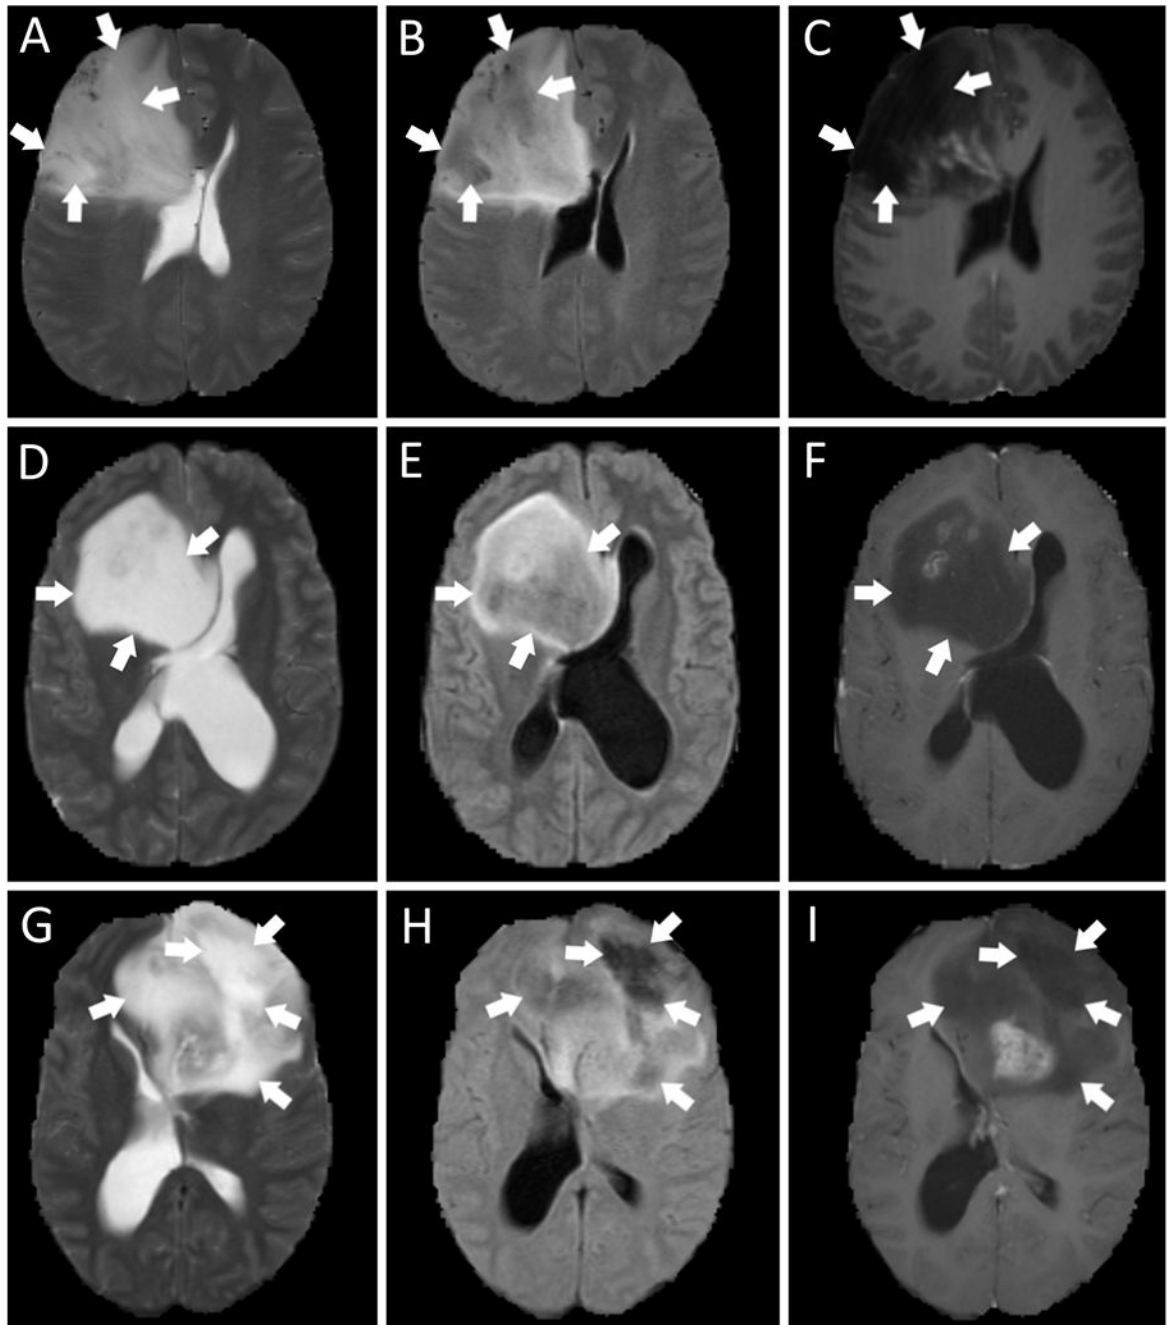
Partial T2-FLAIR mismatch sign in IDH-mutant cases with T2-weighted (A, D, G), FLAIR (B, E, H), and postcontrast T1-weighted images (C, F, I). Each case has T2-hyperintense signal corresponding to FLAIR-hypointense signal in non-enhancing portions of the tumors.
